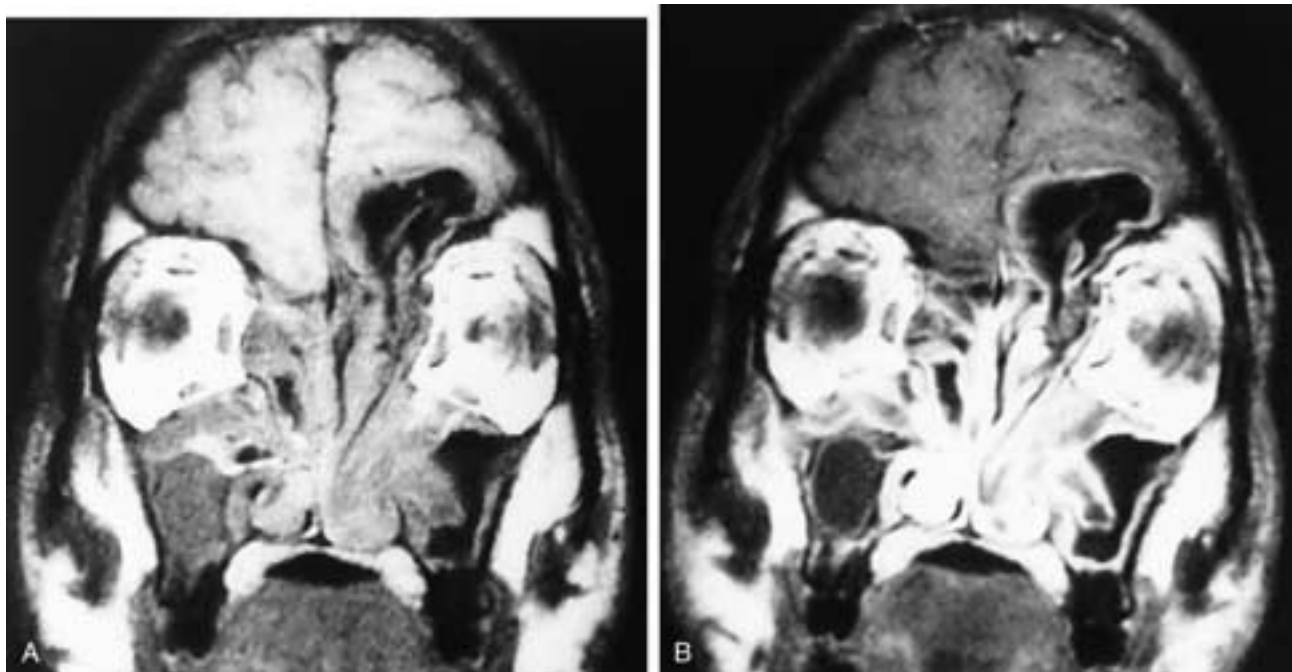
Coronal T1-weighted MR images without contrast (A) and with contrast (B). There are polypoid masses in the nasal fossae, the maxillary sinuses, and the ethmoid complexes. The disease has broken intracranially on the left side. There are areas of high, intermediate, and low signal intensity. In B, the mucosal surfaces of the polyps enhance. This patient had polyposis.
